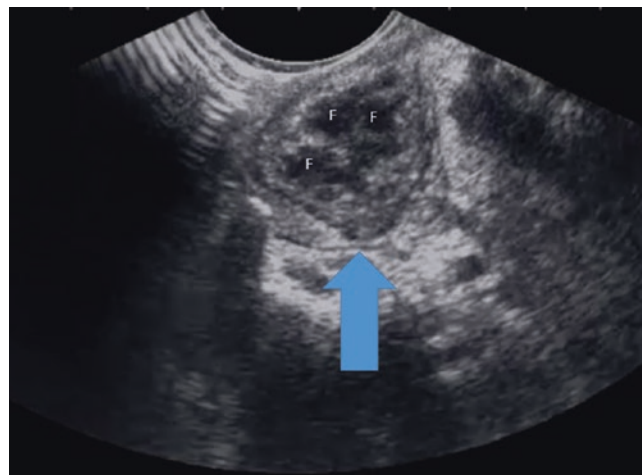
IOU ultrasound: The blue arrow marks the abscess filled with fluid (F). Image courtesy of Phillip Andrus
